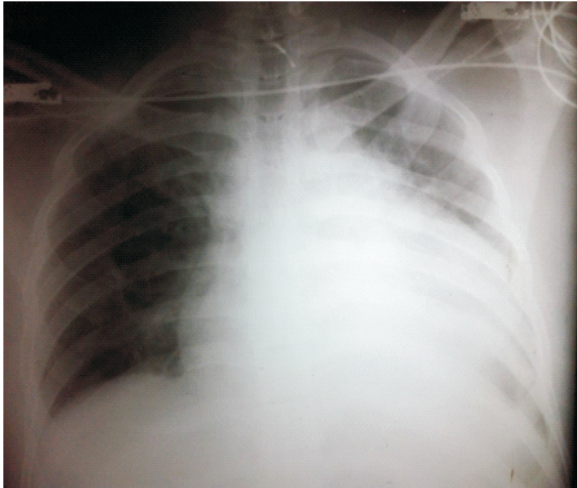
Chest radiograph on day 15 of the illness showing evidence of a massive pericardial effusion
